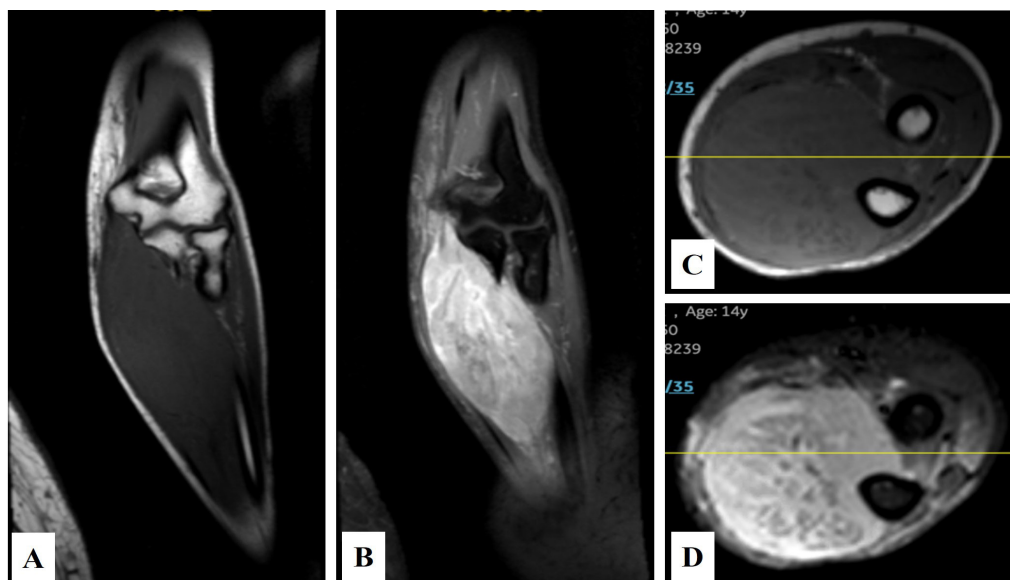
Case 2. MR images of the left forearm: (A) Coronal T1-weighted (T1WI); (B) coronal T1WI post-gadolinium; (C) axial T1WI, and (D) axial STIR. The images revealed a heterogeneous, lobulated mass in the volar compartment extending from the common flexor tendon to the mid-forearm. The lesion appeared iso-hypointense on T1WI (A and C), hyperintense on T2-weighted imaging, heterogeneously enhanced post-contrast (B), and not suppressed on STIR (D).
